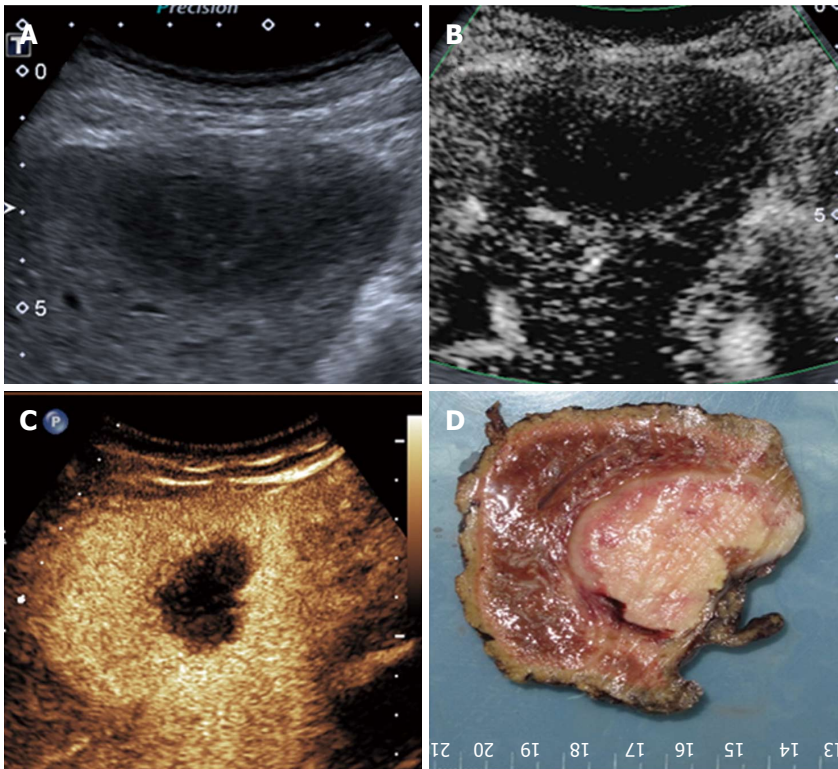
Thick rim type (type VI) in a 71-year-old male diagnosed with primary hepatic lymphoma. A: A low-echo lesion with a relatively clear margin was evident in the left liver lobe; B: SMI showed a thick rim-distributed microvascular structure; C: Contrast-enhanced ultrasound showed thick rim enhancement of the lesion in the arterial phase; D: The gross pathology result showed a thick rim distribution of the vasculature. SMI: Superb microvascular imaging.
